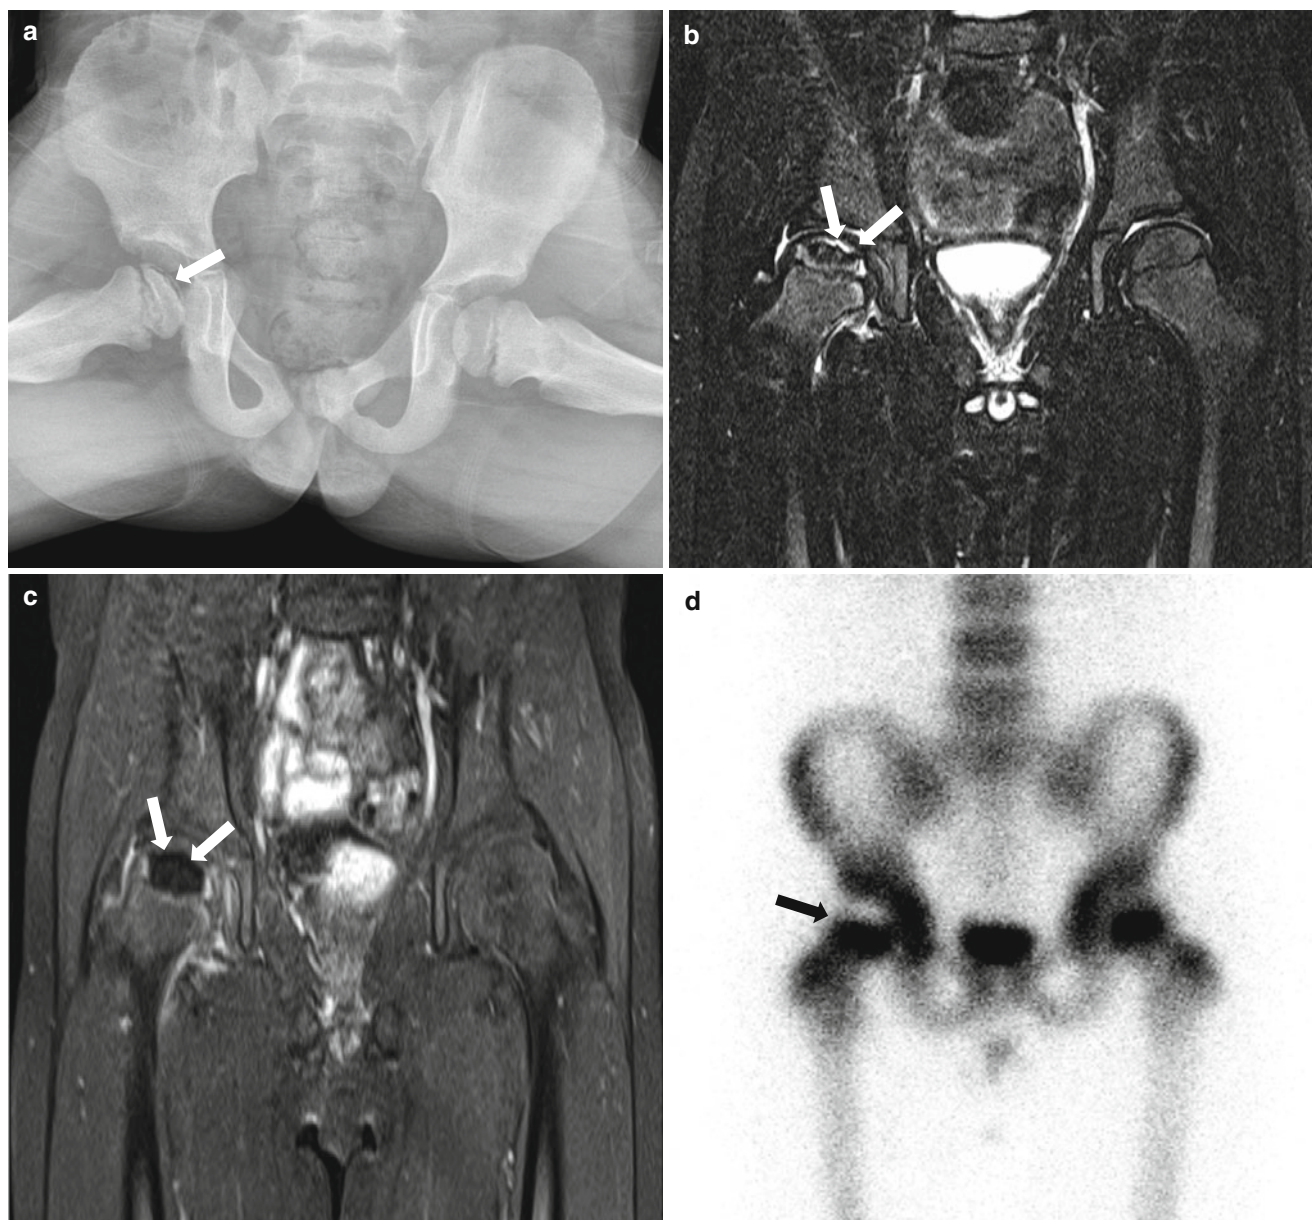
MRI appearance of an early-stage LCP disease. (a) Frog-leg lateral view of a 7-year-old boy shows collapsed femoral head with sclerosis in the right hip joint. Note the subchondral radiolucency (arrow). (b) Coronal T2-weighted MR image shows heterogeneous signal intensity of the right proximal femoral epiphysis with crescent
